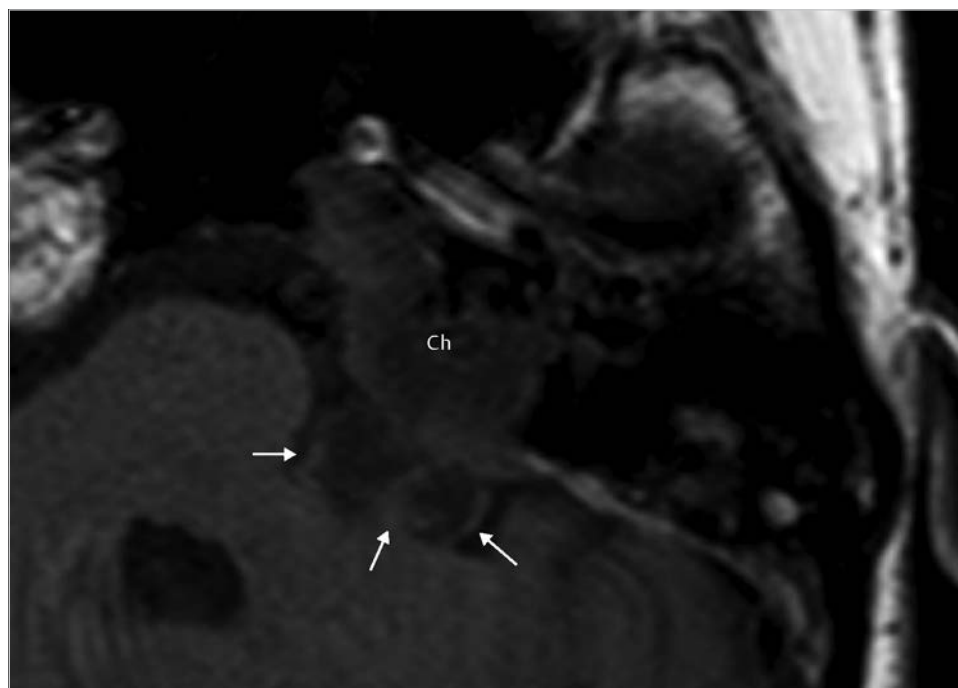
The MRI shows compression of the brain stem by cholesteatoma protruding from the petrous apex (*arrows*). Ch, cholesteatoma.
